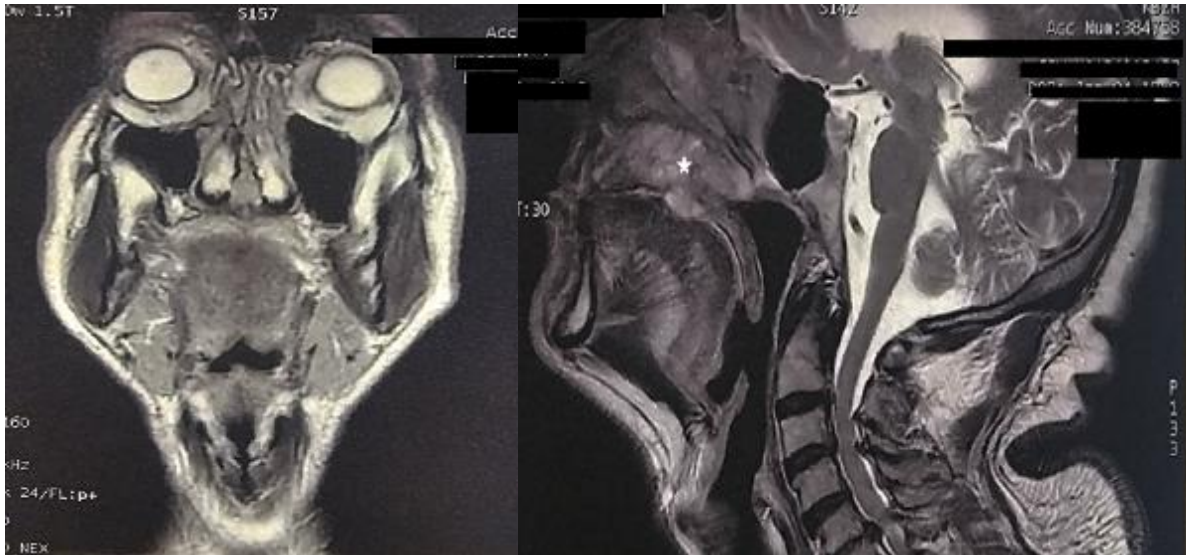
Axial and sagittal T2-weighted MRI demonstrating a well-defined mass of the hard palate (Star), with no evidence of invasion into the adjacent soft tissues or sinonasal extension
